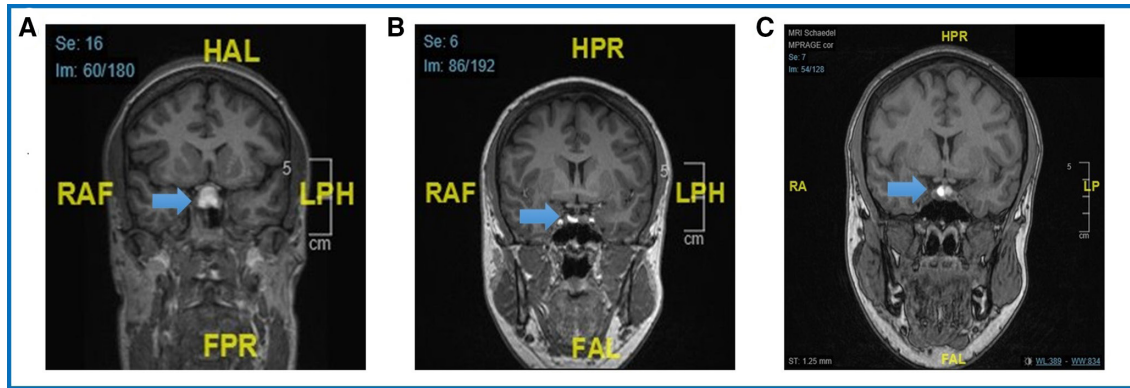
(A) Coronal view of T1-weighted imaging of first event, (B) coronal view of T1-weighted imaging postpartum, (C) coronal view of T1-weighted imaging of second event.
